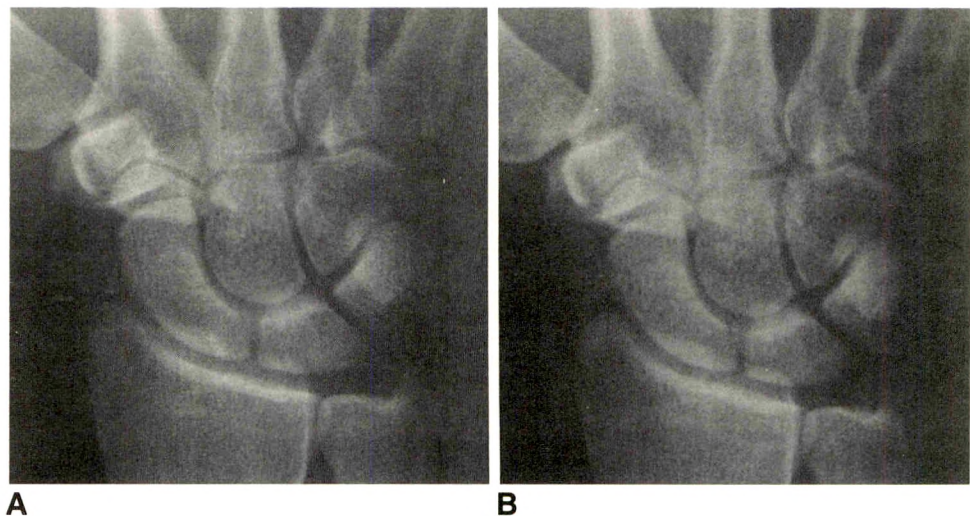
A, Original radiograph of wrist of 17-year-old boy with undisplaced, linear fracture of carpal navicular bone.
